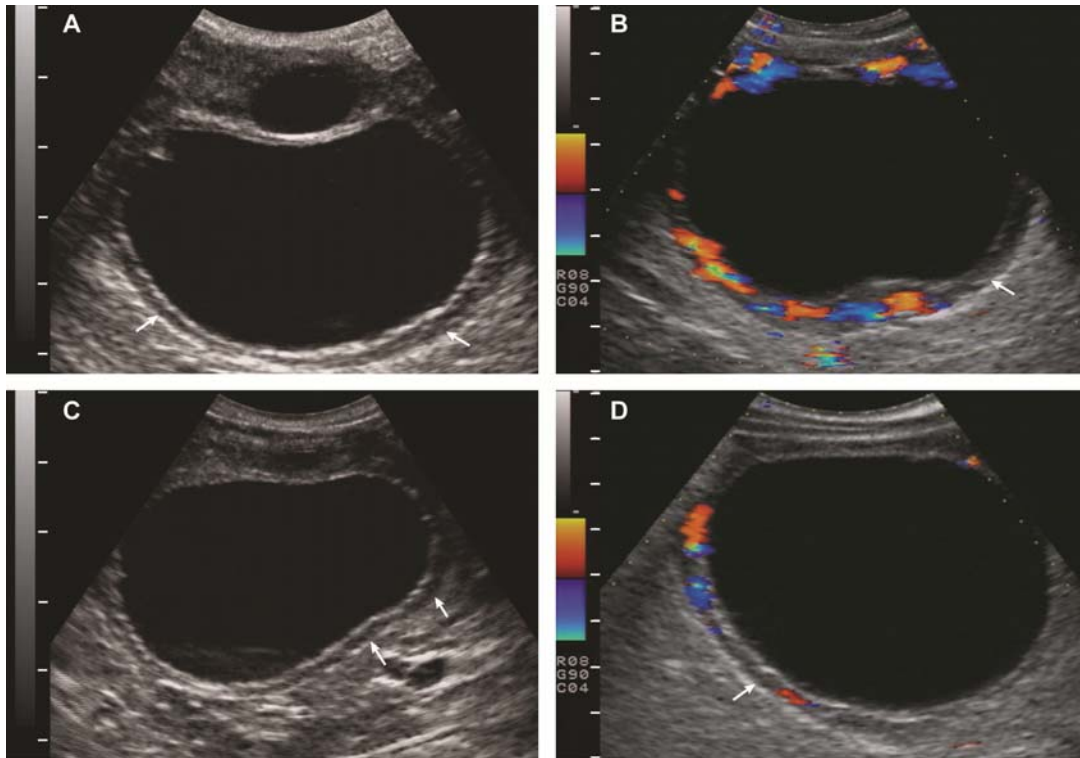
B-mode ultrasonograms (A, C) of preovulatory follicles of two mares at 2 days after the largest follicle reached ≥ 35 mm and 1 day before ovulation. Note the presence of the anechoic band (arrows). Color-Doppler ultrasonograms (B, D) of preovulatory follicles of two mares at 4 days after the largest follicle reached ≥ 35 mm. Images were taken at 2 days (B) and 3 hours (D) before ovulation. Note the anechoic band (arrows) and color-Doppler signals located within or extending beyond the width of the anechoic band. All images have been magnified to improve visibility of the anechoic band. Adapted from Gastal et al. (2006a).
